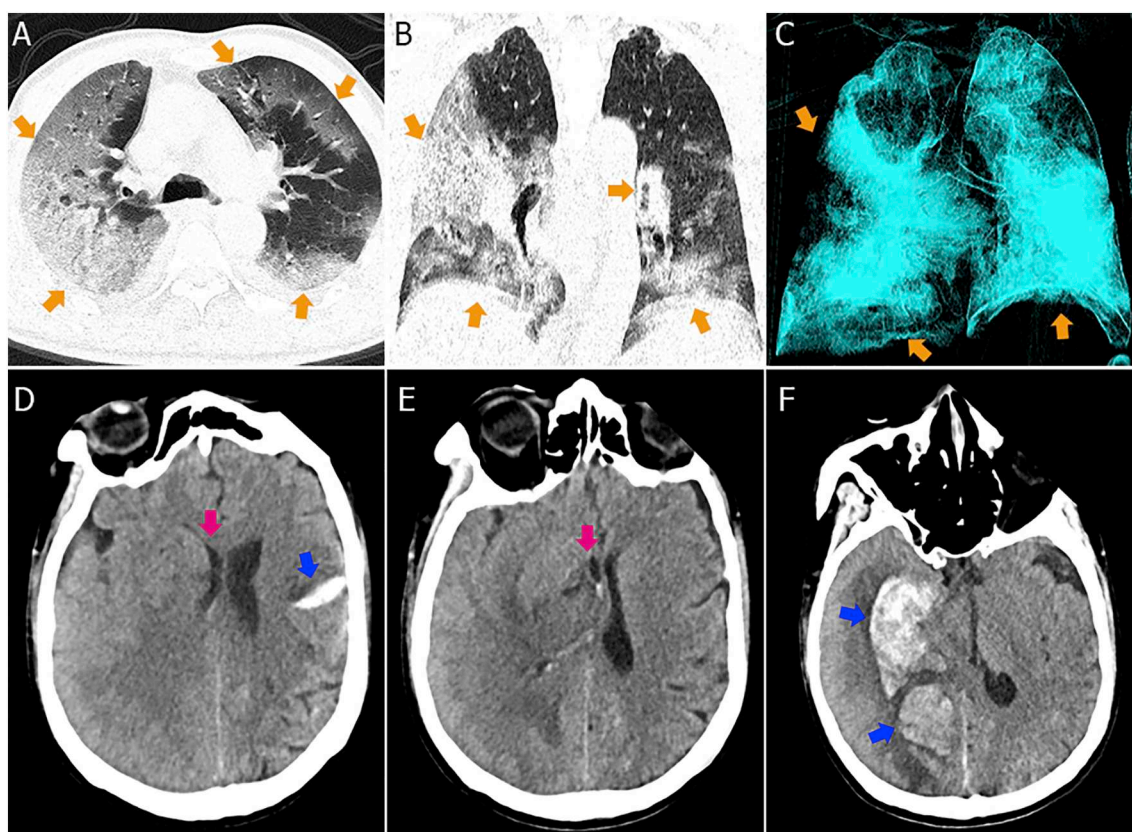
Chest and head CT images of the COVID-19 patient. (A, axial chest CT scan; B, coronal chest CT scan; C, chest CT image of volume rendering technique; D–F, head CT scans.)
